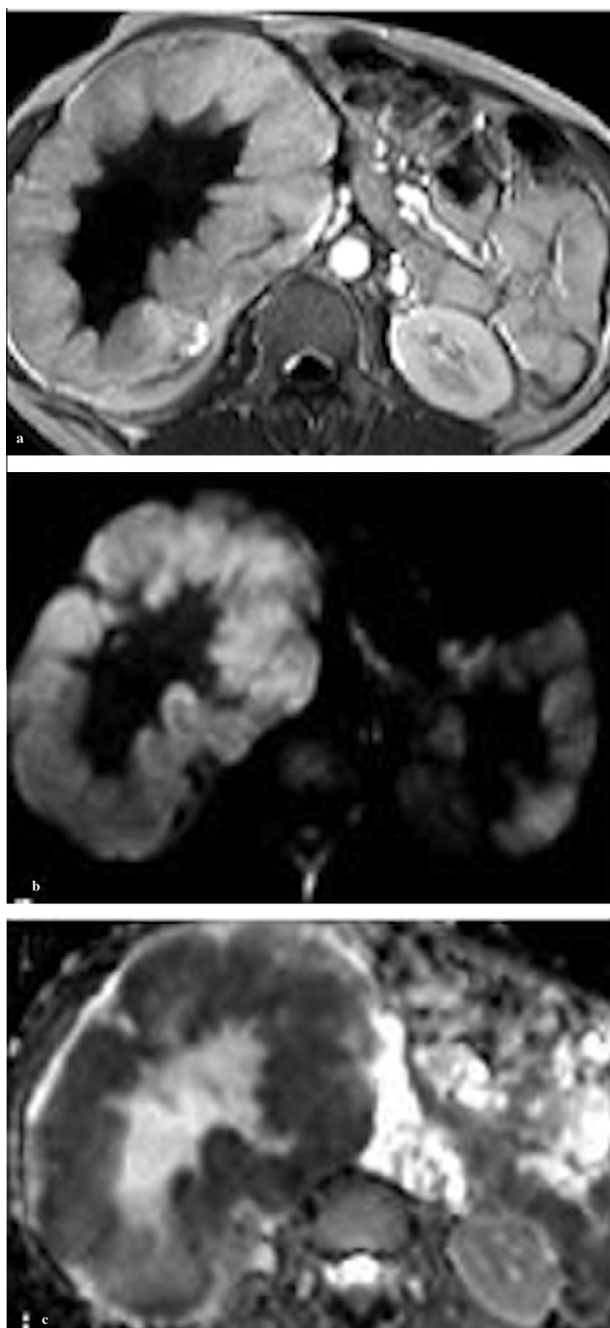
A 37-year-old male with chromophobe RCC. (a) Post-contrast axial T1WIs show heterogenous enhancing large exophytic right renal lesion with nonenhancing central region. (b) DWI at b value of 800 and (c) ADC map show restricted diffusion of the peripheral solid part and facilitated diffusion of the central region. The ADC values of the peripheral solid component and central region are $1.27 \times 10^{-3} \text{ mm}^2/\text{sec}$ and $2.8 \times 10^{-3} \text{ mm}^2/\text{sec}$ respectively.
